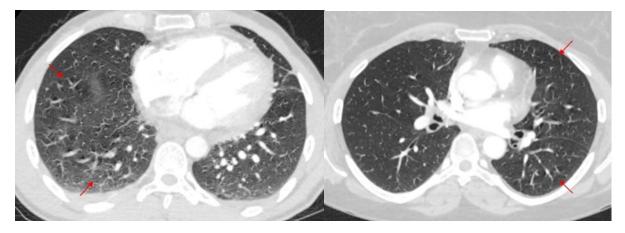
Minor motion artifact. Example axial CT images in lung window settings. Red arrows indicate examples of motion artefact.
